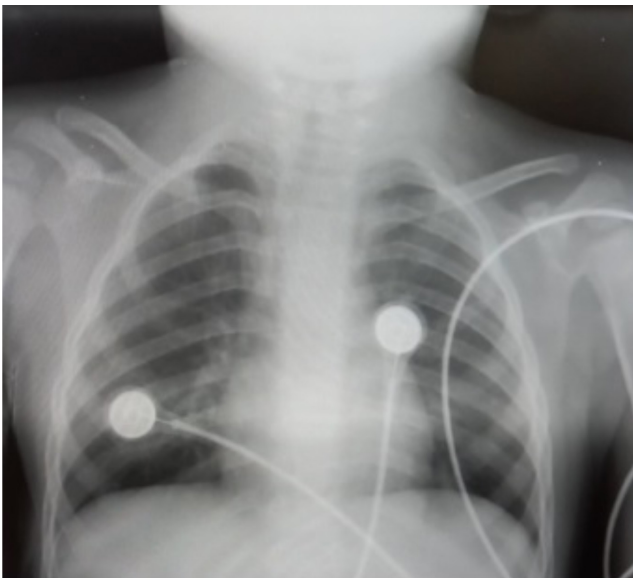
Bilateral infiltration and increased aeration on chest X-ray
